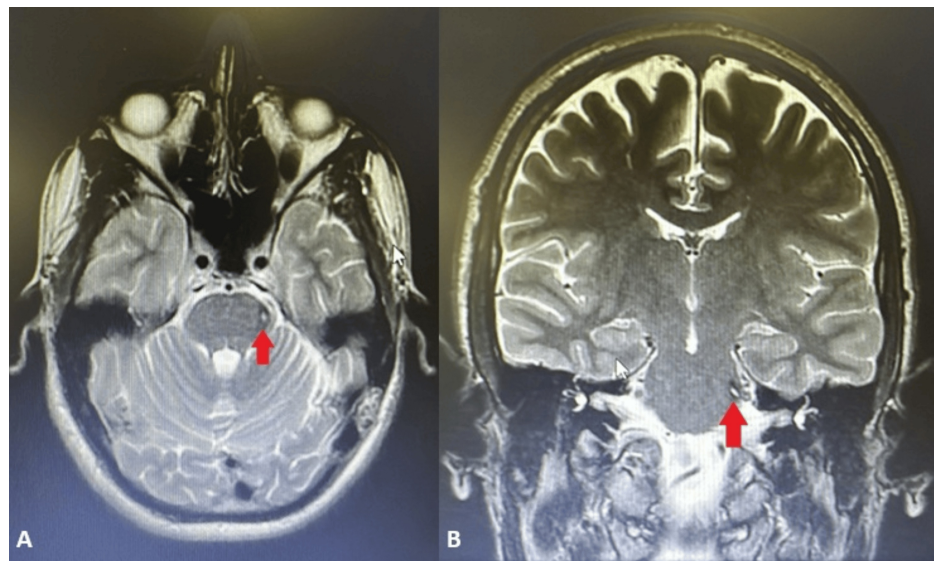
Postoperative T2-weighted MRI demonstrating expected postoperative changes in the left pontine region. No residual cavernous malformation is visible, confirming gross-total resection (red arrow). (A) Axial T2-weighted MRI. (B) Coronal T2-weighted MRI.
